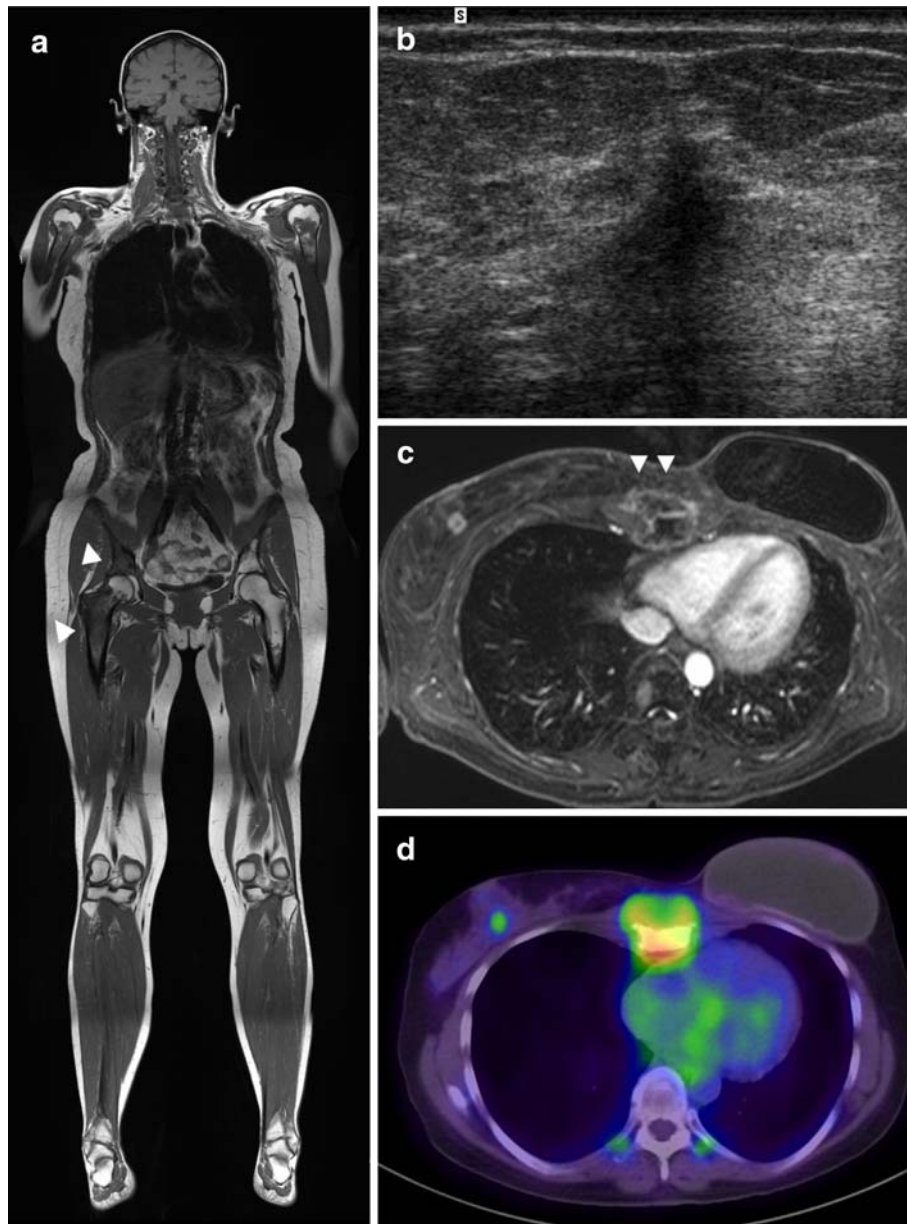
45-year old woman with breast cancer and suspicion of tumor recurrence in breast radiographs/ultrasound during routine screening. A) Coronal whole-body T1w-TSE-imaging on four body levels at 1.5 Tesla shows large hypointense bone marrow lesions indicating bone metastases in the right proximal femur and acetabulum (arrowheads). B) Previous breast ultrasound showed an ill-defined hypoechoic lesion (18 mm), suspicious of tumor recurrence of invasive-ductal carcinoma. C) 3D-VIBE-MRI in late venous phase at the anatomic level of the breast depicts an enhancing mass in the right breast indicating contralateral tumor recurrence. Additionally, a large sternal bone metastasis is described (arrowheads). D) PET-CT correlation of the thorax reveals pathologic FDG-uptake in the right breast lesion (SUV 3.2) as well as the sternal mass, confirming malignancy. Bilateral uptake in the facet joints is of degenerative nature.
